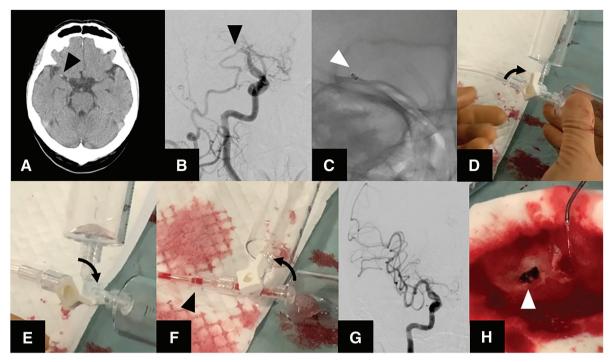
(A) CT shows high-density area in the right middle cerebral artery (arrowhead). (B) Angiography shows proximal occlusion of the right middle cerebral artery (arrowhead). (C) SOFIA Flow Plus was navigated to a position to the occlusion site using CHIKAI and Marksman. Arrowhead: tip of the SOFIA Flow Plus. (D) The three-way stopcock was opened (arrow), and suction was initiated. (E) After 15 seconds, the direction of the three-way stopcock was switched (arrow). In the meantime, the negative pressure through the syringe was reapplied. (F) The direction of the three-way stopcock was switched (arrow). At this time, the blood and air in the tube were removed considerably (arrowhead). After repeating this procedure twice, SOFIA Flow Plus was removed. (G) Angiography showed complete recanalization (TICI 3). (H) A red clot was confirmed in the syringe (arrowhead). TICI: thrombolysis in cerebral infarction
